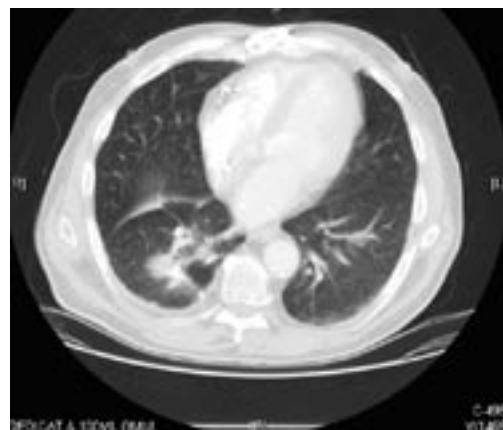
Chest CT scan demonstrating a mass in the right lower lobe. Wedge resection of this mass revealed metastatic adenocarcinoma consistent with a gastrointestinal primary.
